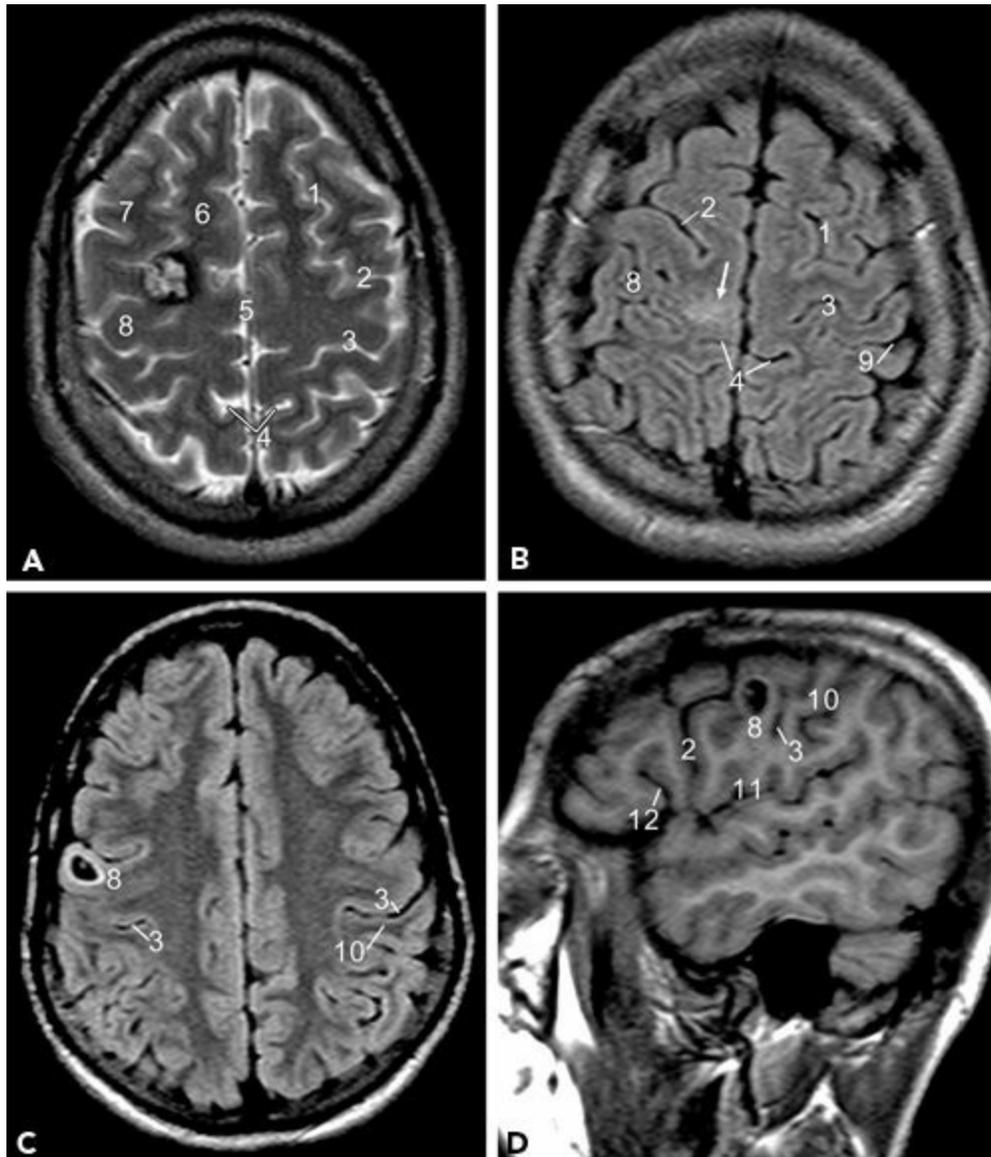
Lesions around the region of the central sulcus and precentral gyrus. A: T2-weighted image shows a cavernoma at the junction of the right superior frontal gyrus and precentral gyrus. B: FLAIR image shows an area of hyperintensity over the paramedian precentral and postcentral gyrus. C, D: A cystic lesion in the precentral gyrus over the lateral convexity displayed in axial and sagittal planes. (1, Superior frontal sulcus; 2, precentral sulcus; 3, central sulcus; 4, marginal sulcus; 5, interhemispheric fissure; 6, superior frontal gyrus; 7, middle frontal gyrus; 8, precentral gyrus; 9, postcentral sulcus; 10, postcentral gyrus; 11, sylvian fissure; 12, anterior rami of sylvian fissure.)
